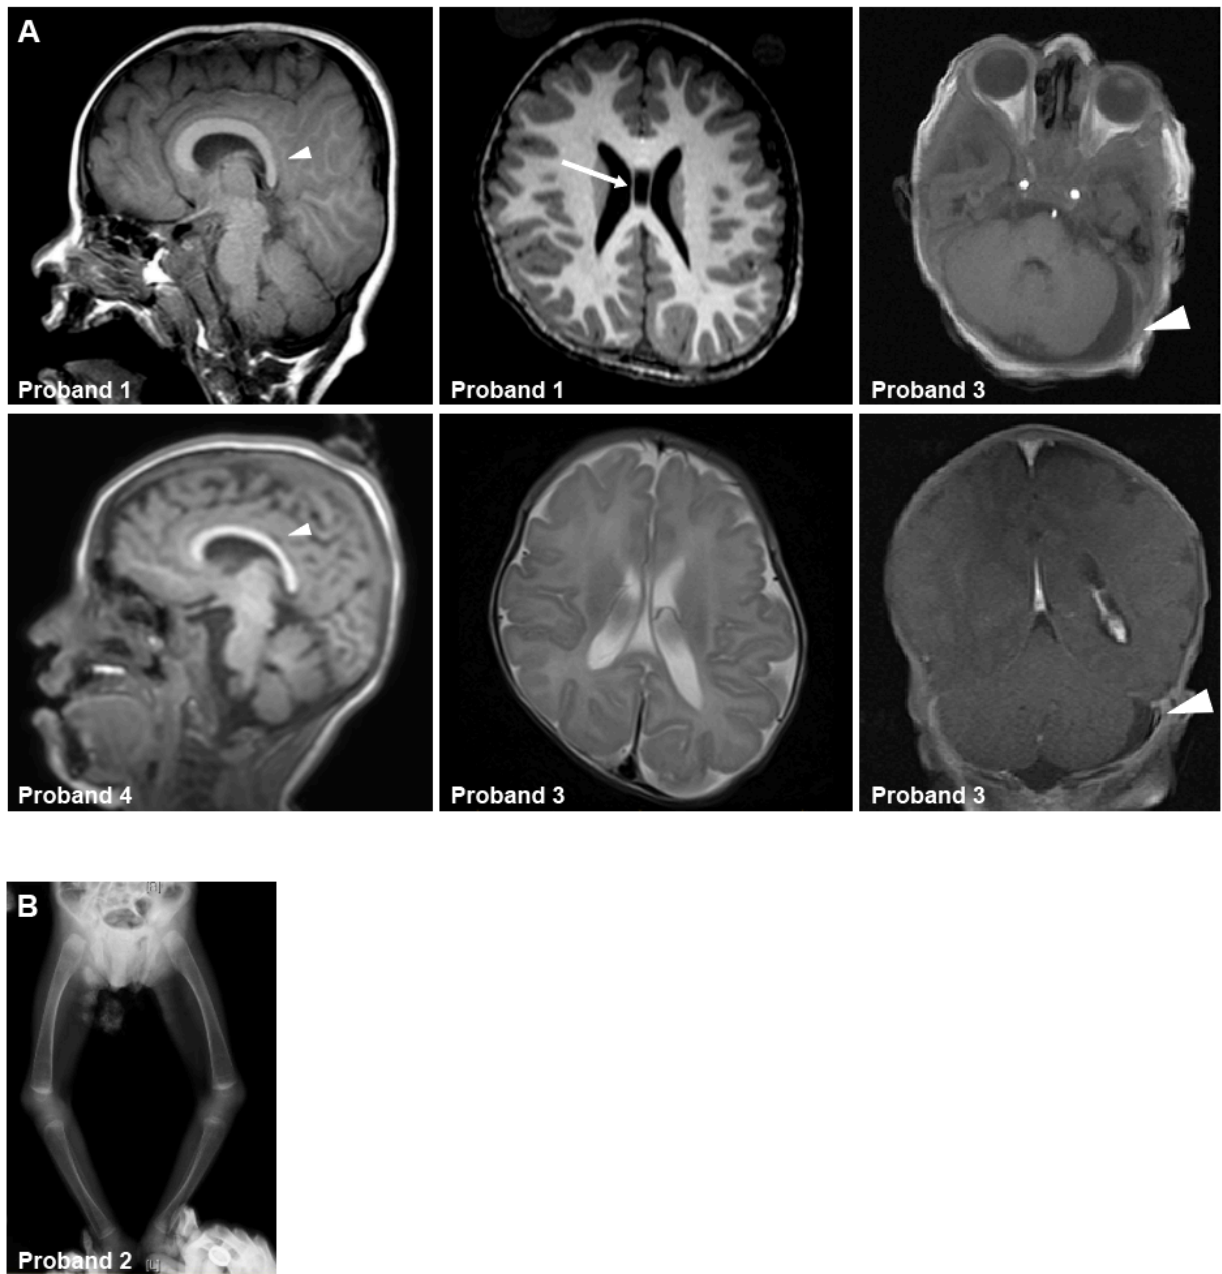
Radiographs of individuals with bi-allelic loss-of-function *CCDC47* variants. (A) Brain MRIs of Probands 1, 3, and 4. Note the thin corpus callosum in Probands 1 and 4 (small white arrowheads in the sagittal plane, left panels), cerebral atrophy in Probands 1 and 3 (transverse plane, center panels), and mild prominence of the third ventricle in Proband 1 (white arrow in the transverse plane, center upper panel). There is a stable mild prominence of cerebrospinal fluid surrounding the left cerebellar hemisphere in Proband 3 (large white arrowheads in the transverse and coronal planes, right panels). (B) An x-ray of the lower extremities of Proband 2 shows evidence of osteoporosis.
